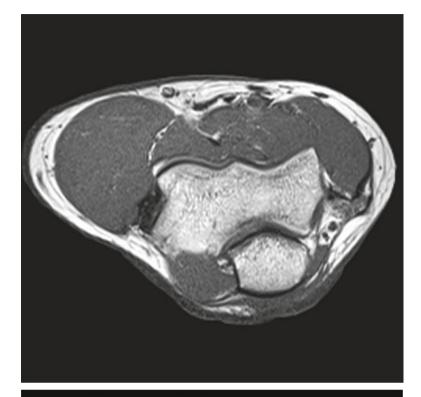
MRI scans at the distal third of the arm through the ulnar nerve
